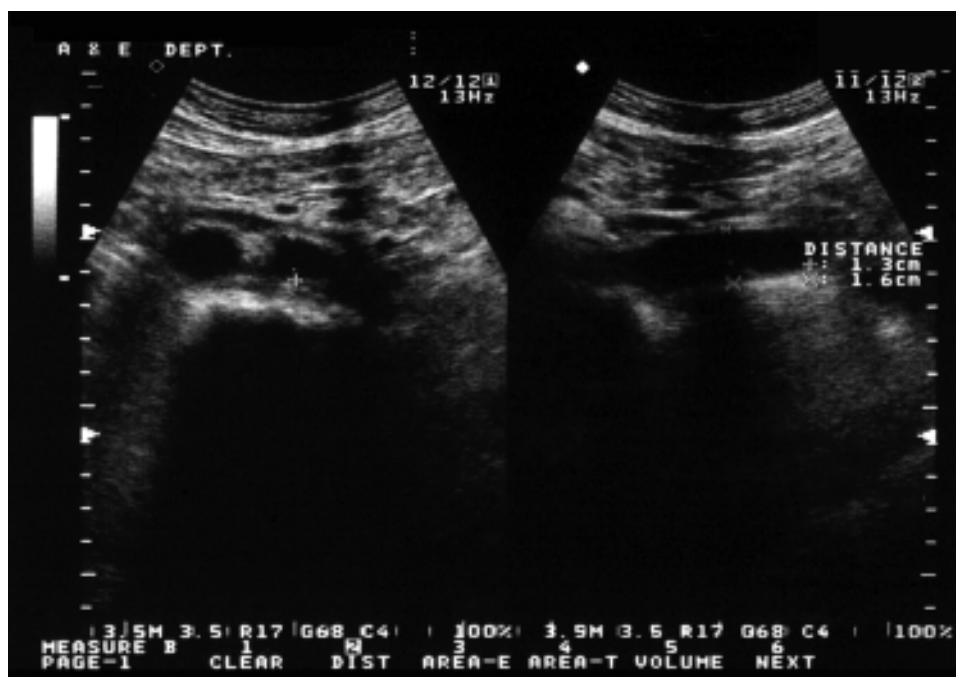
Emergency ultrasound focused on patient's abdominal aorta, showing no aneurysm. Left: transverse section. Right: longitudinal section.
